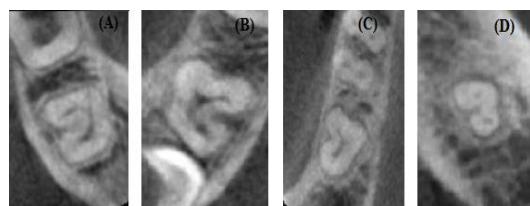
CBCT images of teeth with canal anatomy . (A) at canal orifice, (B) coronal third level, (C) mid root level, (D) apical third level.
